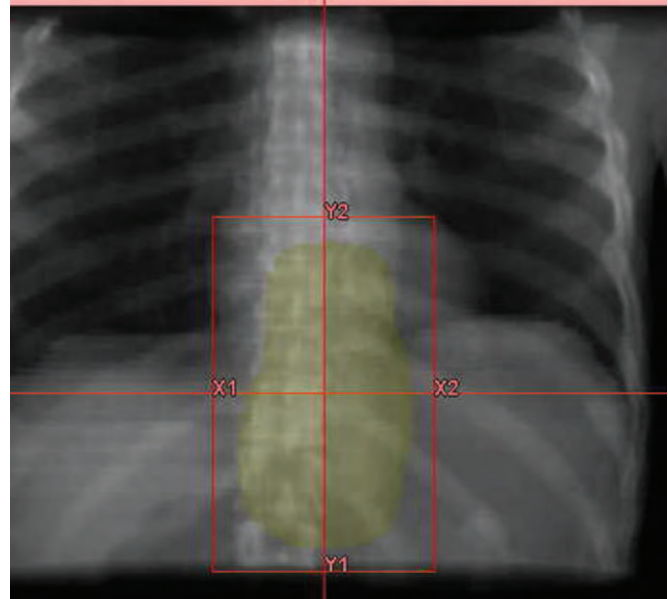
Palliative radiation field demonstrated on a digitally reconstructed radiograph. Field borders encompass the contoured volume of the tumor plus an appropriate margin. (Courtesy of Dr. R. Bulusu.)
